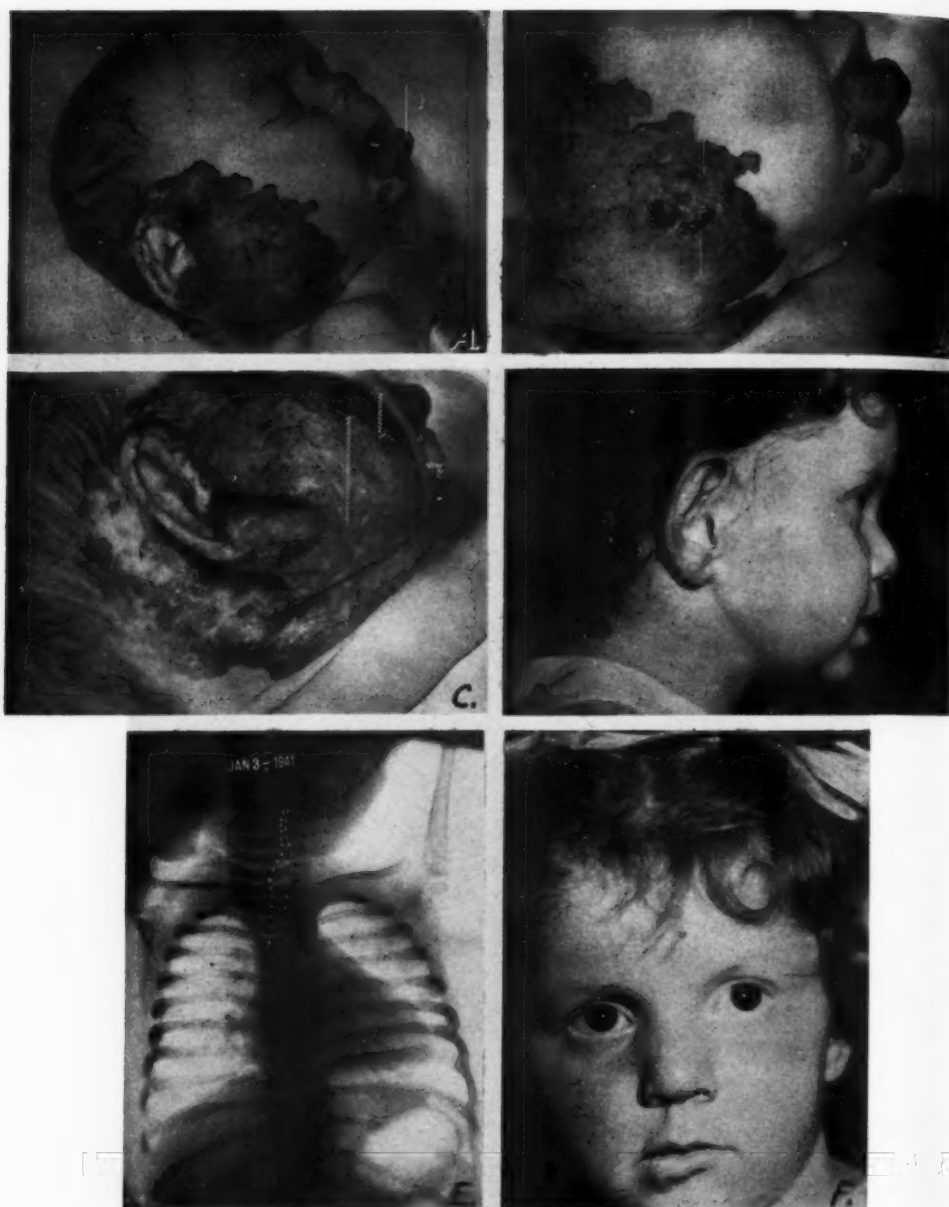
Case III: J. H., female, age 8 months, referred by W. R. Little of Trenton, N. J., on Jan. 3, 1941. A, B, and C. Cavernous hemangioma involving almost the entire right side of the face, neck, lip, and chin; lesions also on the left side of the scalp and left arm. None of these was present at birth. The first lesions appeared on the lip at the age of six to eight weeks and on the right cheek at about three months. They had grown rapidly since. In June 1940, lesions appeared on the left temporal region and on the left arm. The patient was in the Jefferson Hospital in July 1940, under the care of Dr. Warren B. Davis, on account of right middle ear disease, which he treated successfully. While in the hospital, the child began to wheeze, and by bronchoscopic examination Dr. Clerf found obstruction in the trachea due to pressure of a tumor on the right side of the neck. An x-ray film of the chest (E) showed compression by the tumor against the trachea and the larynx, but there was no tumor formation within the chest. The case looked so hopeless that I at first refused treatment. The child was brought back on Jan. 21, 1941, when treatment was urgently requested by the parents. The following radium applications were made:
